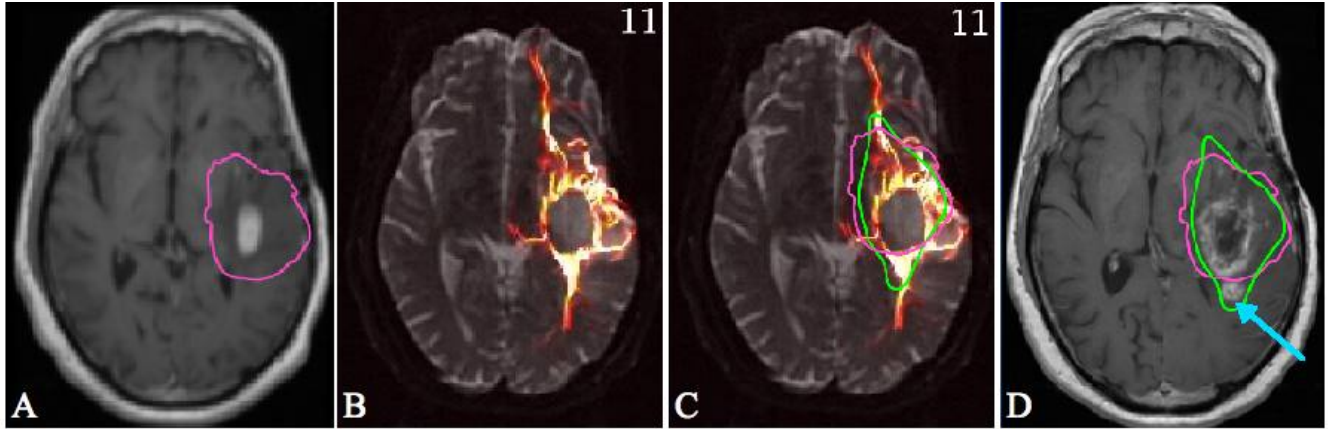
Depiction of cell migration model results for retrospective case of anaplastic astrocytoma. [A] T1 weighted post-contrast image showing the primary anaplastic astrocytoma and treatment margin (pink line - 90% isodose) obtained from the CT treatment plan. [B] Map of cell concentration showing areas of high concentration in yellow and lower concentration in red. The slice number is shown in top right corner. [C] The treatment plan that was used for SRT (pink line) and the proposed anisotropic treatment plan (green line) designed by increasing the dose along areas of high cell concentration (by 1-2cm) and reducing the dose margin given to the surrounding normal tissue. These plans are depicted on the follow-up T1 weighted post-contrast image [D] showing the location of the secondary tumor (aquamarine arrow) within the proposed anisotropic treatment plan (green line).
